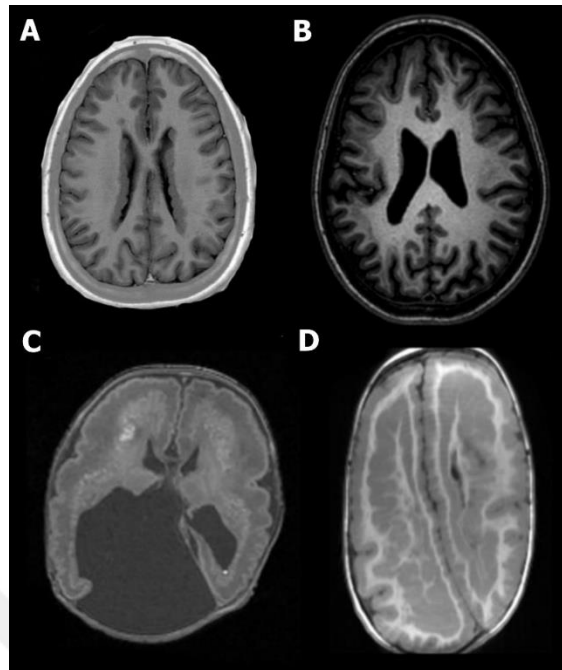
7 MRI images of human heterotopia patients
